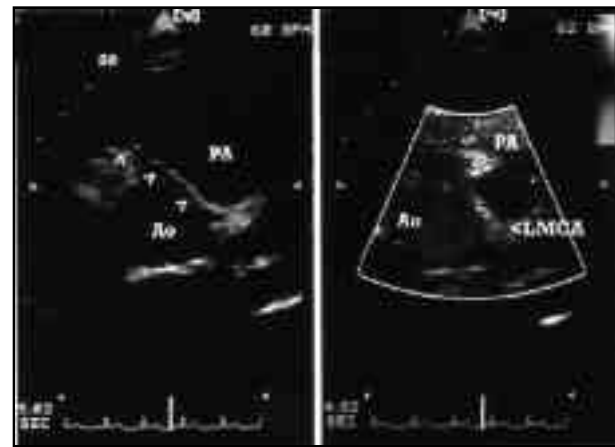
(B) Parasternal short axis view showing the intramural segment of part of the long course of the left main coronary artery (arrowheads). Aorta=Ao, pulmonary artery=PA.
